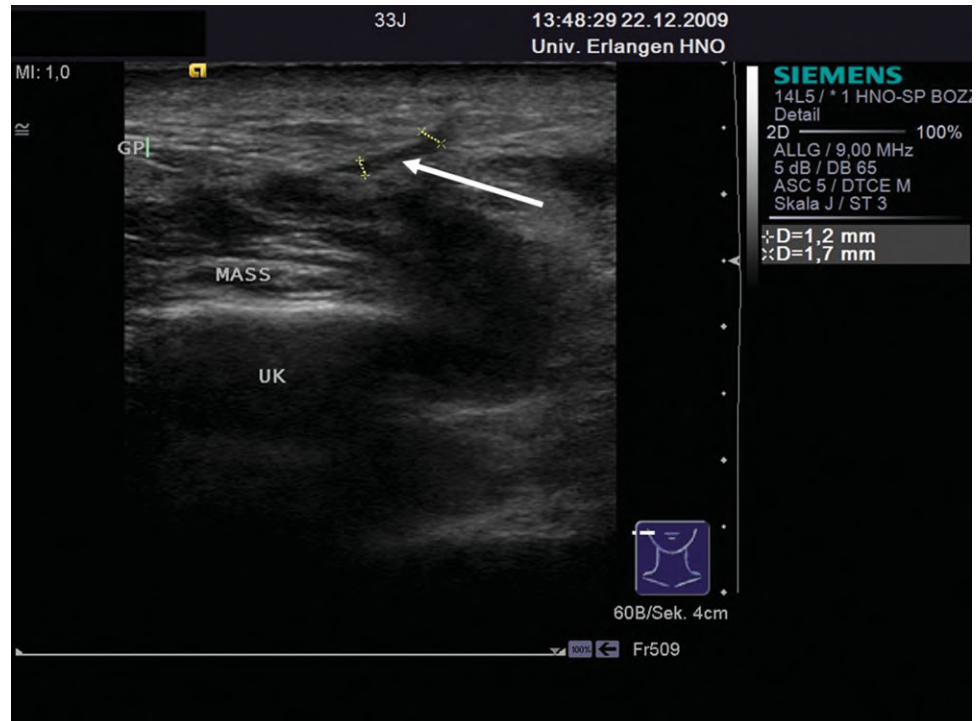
High-resolution ultrasonography. There is a hypoechoic band (diameter, 1.7 mm) that extends from the ductal system to the skin level (white arrow), indicating a fistula between Stensen's duct and the skin. GP = parotid gland; MASS = masseter muscle; UK = mandible. [Color figure can be viewed in the online issue, which is available at [wileyonlinelibrary.com](http://wileyonlinelibrary.com).]
